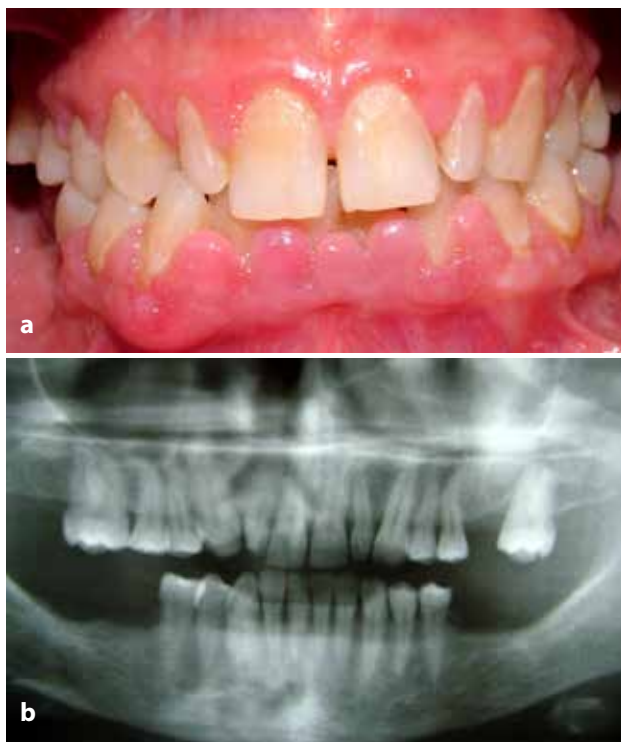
(a) Clinical view on the day the patient presented. (b) Panoramic radiography showing minimal horizontal bone loss.
